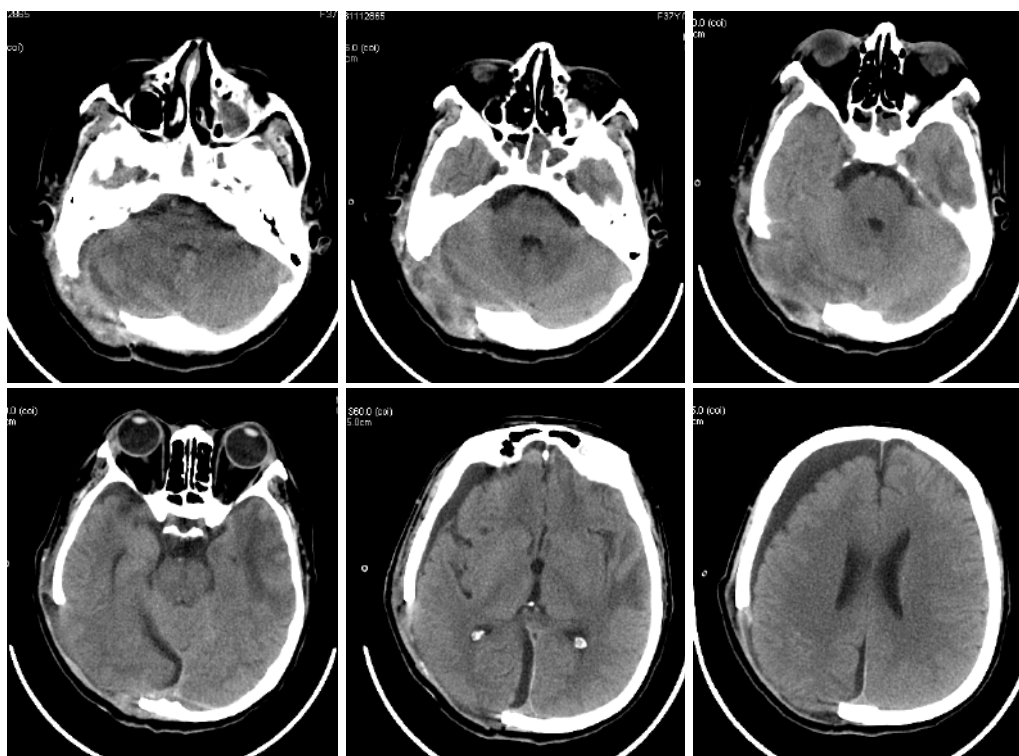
Postoperative head CT reexamination showed cerebral contusion in the left temporal lobe and right occipital lobe, subdural effusion in the right frontotemporal lobe, and skull absence in the right occipital region
